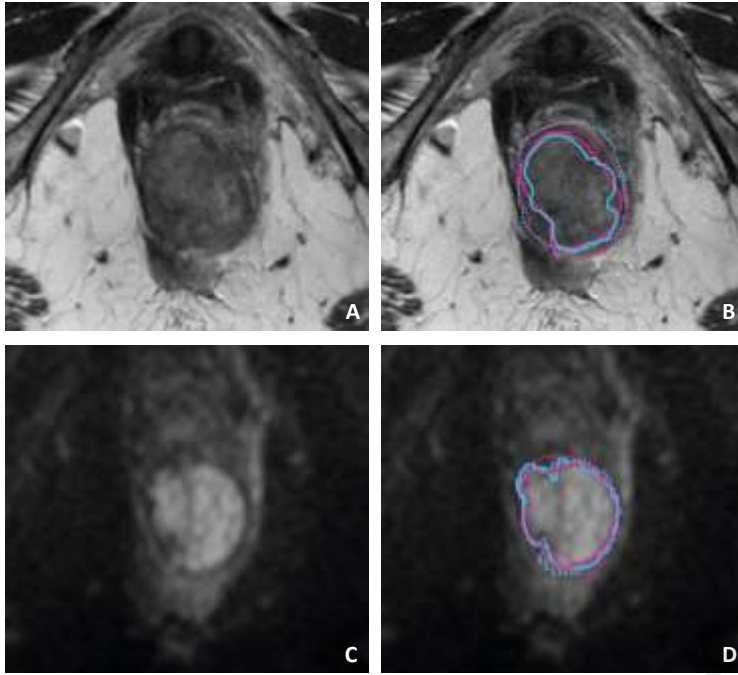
Example of T2W and DWI images of a female patient with a bulky tumour in the anal canal presented without (A,C) and with (B, D) the GTV delineations performed by the four readers: Senior Radiologist (blue line), Junior Radiologist (blue dotted line), Senior Radiation oncologist (pink line) and Junior Radiation oncologist (pink dotted line). In this example, delineations by the senior readers (continuous lines) were smaller than those by the junior readers (dotted lines), in particular on T2W-MRI (B). Delineations on DWI (D) were smaller than on T2W-MRI, especially for the two junior readers and spatial overlap between the four readers was higher in this particular case.
